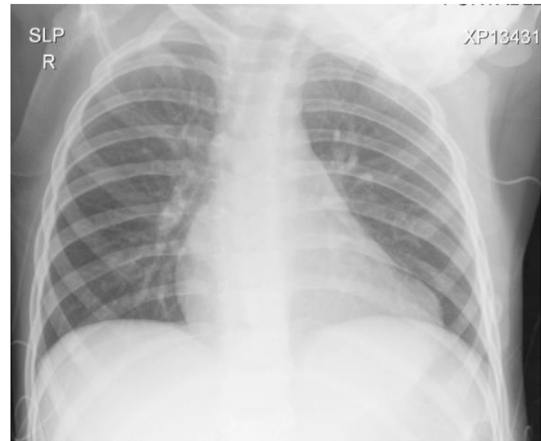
Chest radiograph depicting a slightly enlarged cardiac silhouette.
